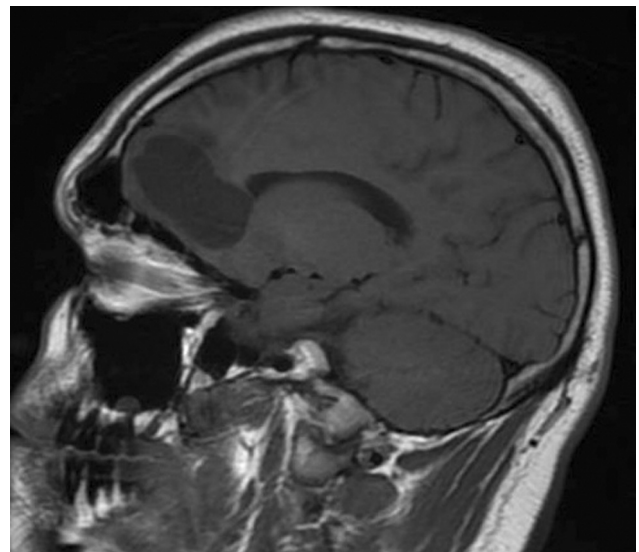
Sagittal MRI scan showing an expansive fronto-basal tumor.
